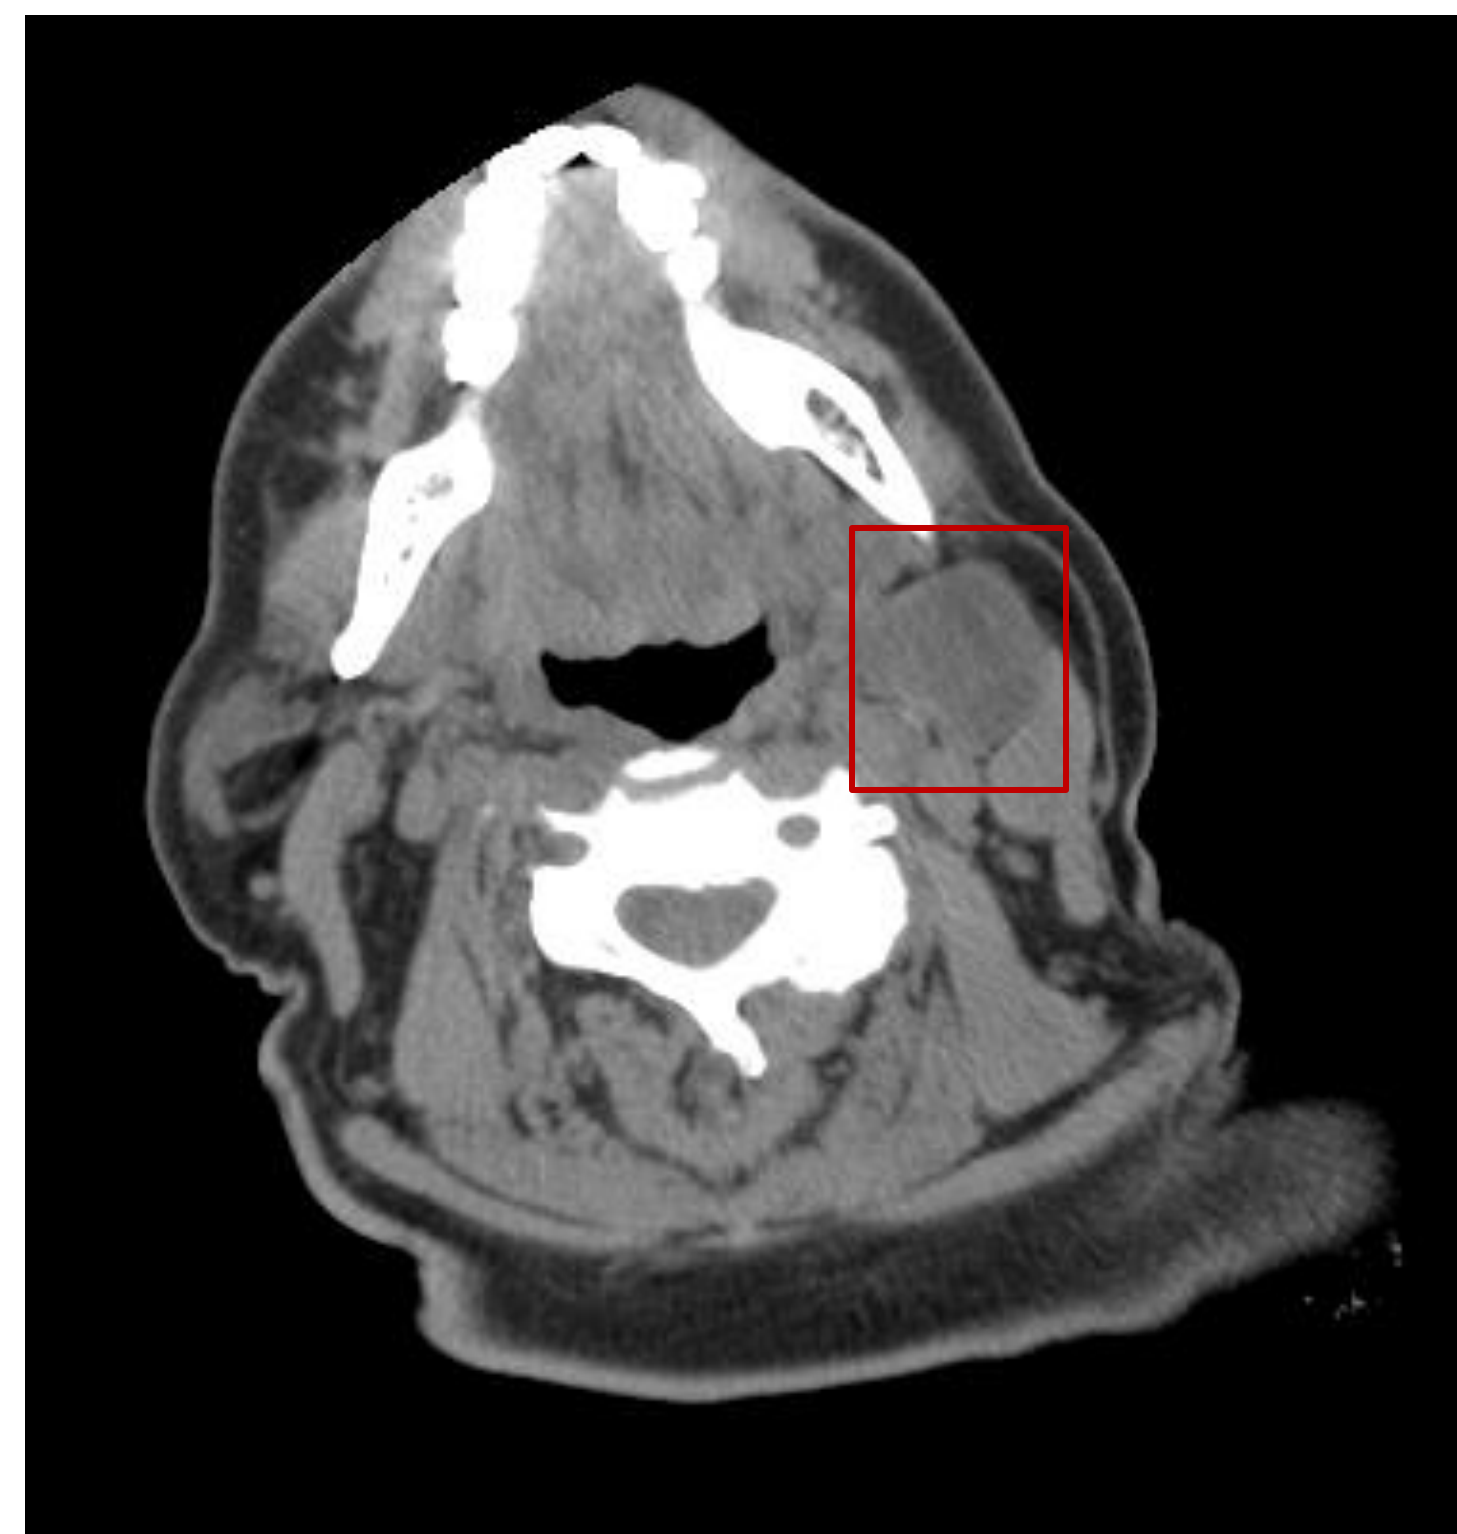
Pre-treatment axial CT demonstrating a cystic L level II mass. No primary was detected on FDG-PET scan.
